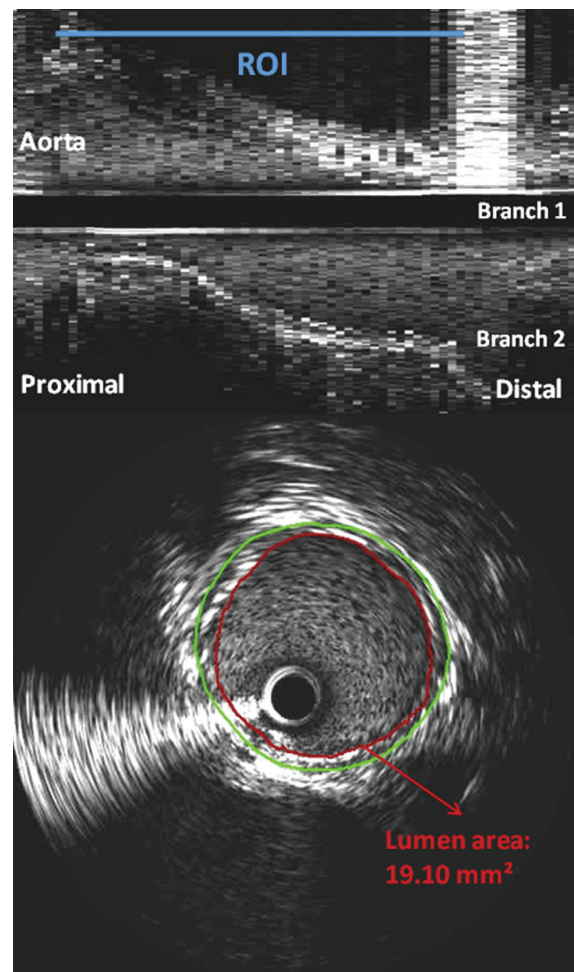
Intravascular ultrasound renal artery. *Black line* represents intravascular ultrasound catheter. *White band* is guidewire artifact. *Red line* represents the lumen area. *Green line* represents the external elastic membrane. ROI, region of interest. (Color version of figure is available online.)
